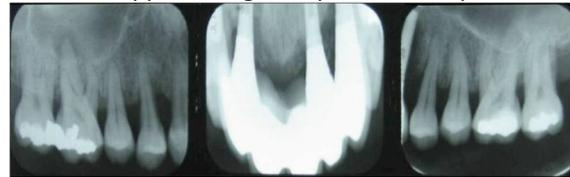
Radiograph case of peri-implantitis with visible loss of vertical bone in implant situation No. 23.
